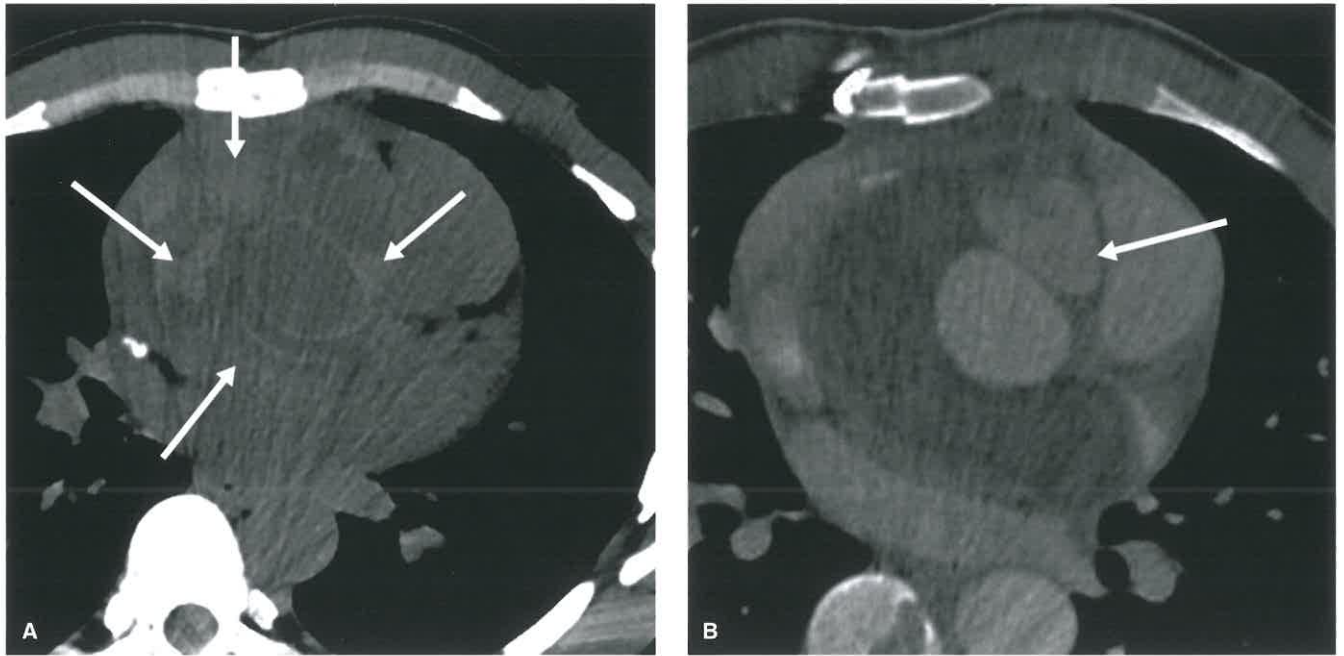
Saphenous Vein Graft Pseudoaneurysm in a 40-Year-Old Man With Worsening Chest Pain 2 Days After Surgery. A: Axial noncontrast image from a gated CTA shows heterogeneous fluid collection surrounding the aortic root with areas of high attenuation suggestive of blood products (*white arrows*). B: Axial image at the same level after administration of contrast shows contrast extravasation near the right sinus of Valsalva (*white arrow*). The patient underwent redo sternotomy which showed that the RCA saphenous vein graft had dehiscence from its aortic anastomosis. Bypass graft pseudoaneurysms are uncommon and usually occur at the anastomotic sites.
